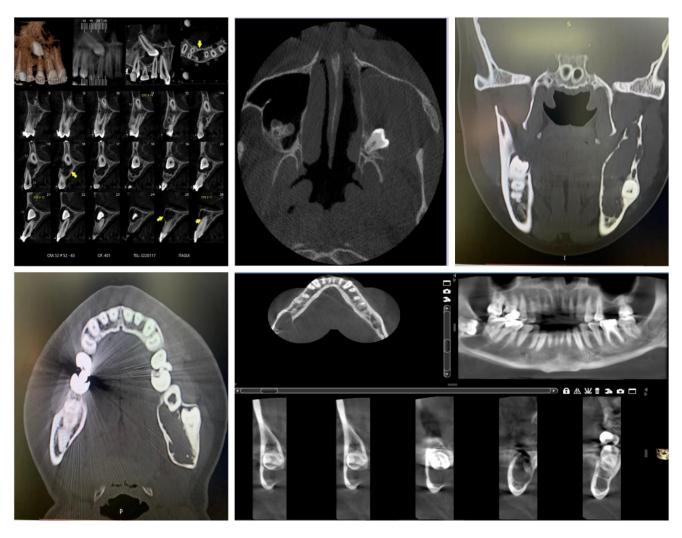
Cone beam computed tomography with odontogenic lesions was studied in this investigation.
